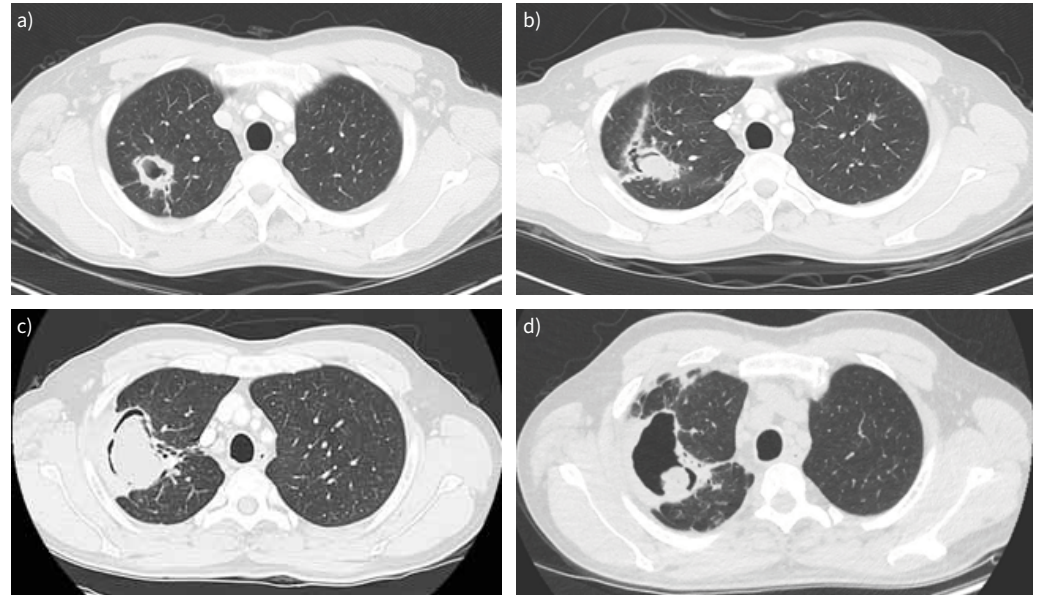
Computed tomography (CT) of the chest (clinical scenario 1). a) CT chest in 2014, showing the residual right upper lobe cavity following completion of tuberculosis treatment. b) CT chest in 2017, showing interval development of a soft tissue density within the pre-existing right upper lobe cavity. c) CT chest in 2021, showing interval enlargement of the right upper lobe cavity and soft tissue density. d) CT chest in 2023, showing a partial response with reduction in soft tissue density after 18 months of therapy with oral itraconazole.
